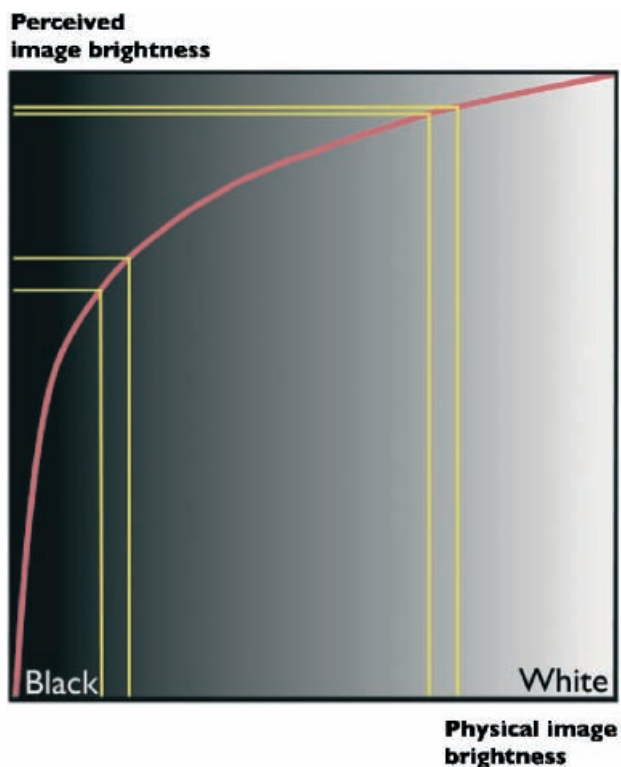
The human eye's response to brightness differences is logarithmic. Therefore, the same physical brightness difference is differently perceived if it occurs against a light background than a dark one. A lesion can therefore be easier to detect when a radiograph is made darker.
